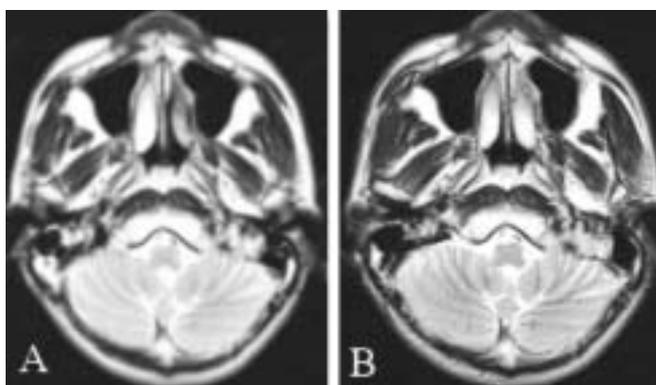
T2-weighted MR images of the brain obtained on May 5, 2004 (A) and on October 26, 2004 (B). In (A), a mild gliosis of the left medial temporal/occipital lobe and that may be due to a prior PCA territory infarction, but no abnormalities in the cerebellum on the both sides. In (B), no abnormalities in the cerebral cortex and cerebellum of both sides are demonstrated.
